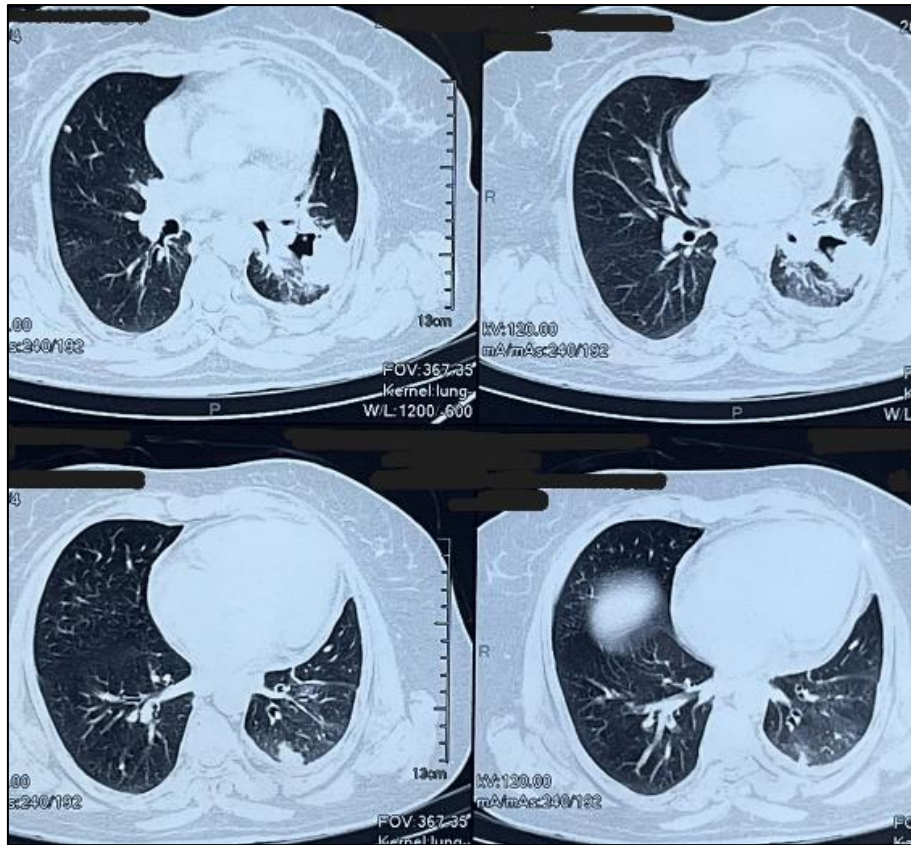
HRCT Thorax showing thick-walled cavity in left upper lobe posterior segment
